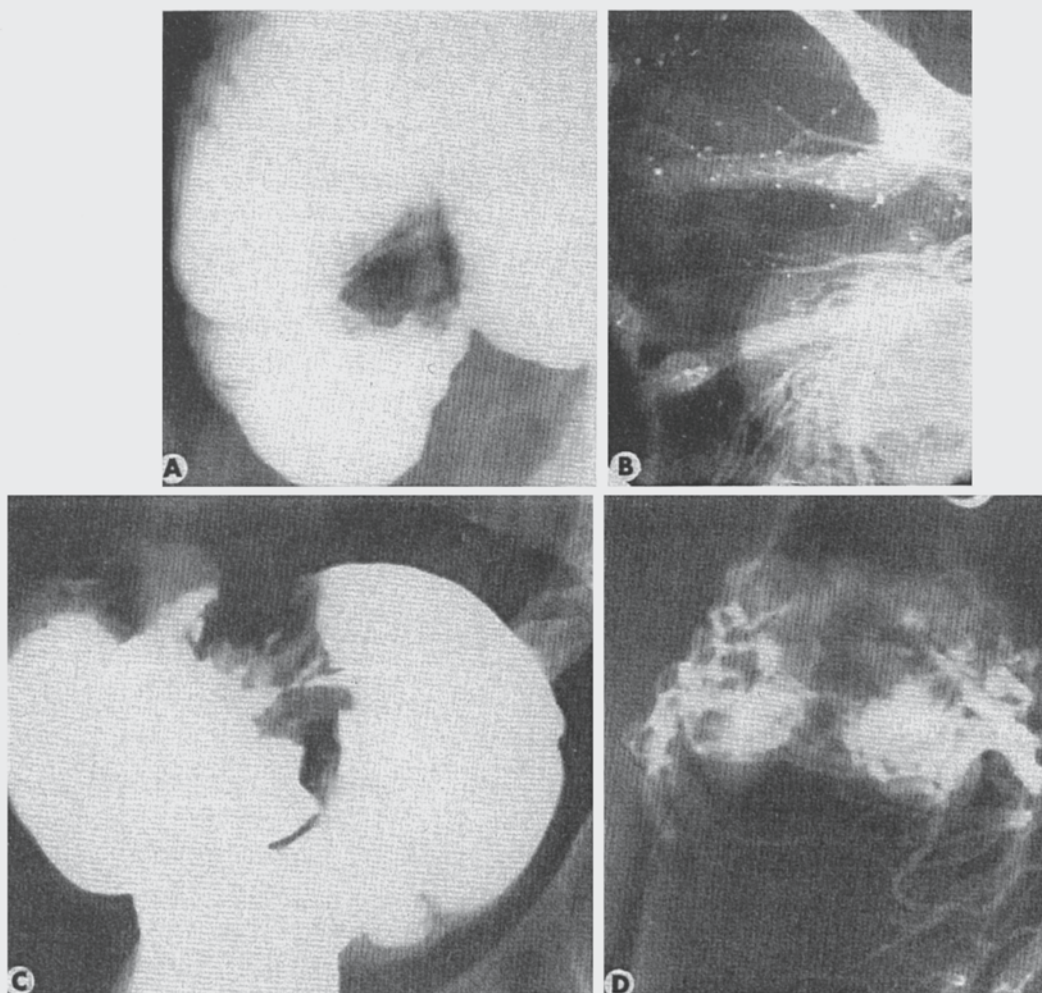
(*A* and *B*) Adenomatous polyps of the cecum. (*A*) A spot roentgenogram during barium enema study showing the large filling defect in the cecum in the region of the ileocecal valve. (*B*) An operative mesenteric arteriogram showing one very large polyp and one smaller polyp. There are multiple winding vessels within the polyps but no areas of perivascular opacity or large areas of laking. The vessels fail to show irregular lumina and do not show sharp turnings. (*C* and *D*) Villous adenoma of the sigmoid. (*C*) A spot roentgenogram of the sigmoid obtained during a barium enema study. (*D*) An operative mesenteric arteriogram of the lesion showing numerous large tortuous vessels throughout the tumor, sharply contrasted with less numerous and smaller parallel vessels in the adjacent normal bowel. No areas of perivascular laking are seen.
